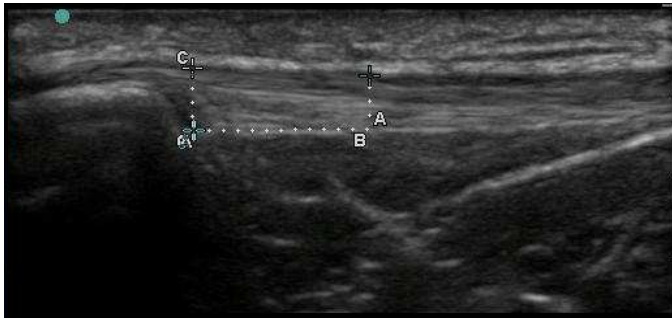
Figure 2 | Sonographic image of measurement site (AP & 1uAP).
